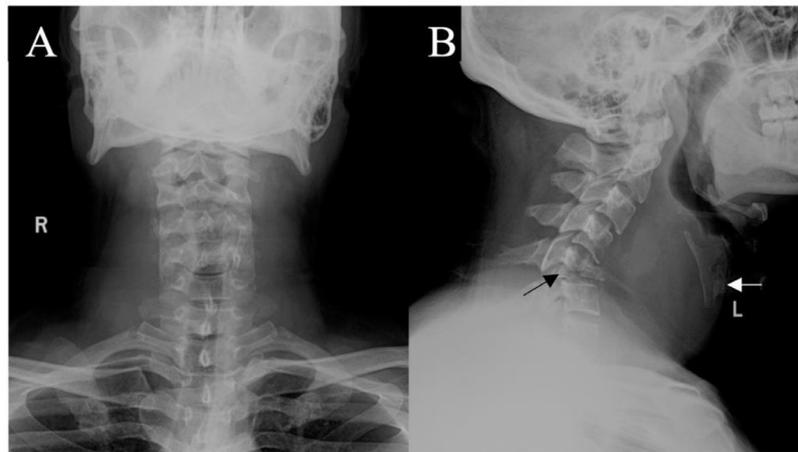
Anteroposterior (A) and lateral (B) radiographs of a 32-year-old male patient diagnosed with synovial sarcoma in the retropharyngeal space. (A) showed a large mass in the neck. (B) showed a large mass in the prevertebral space with the fifth cervical spine pathological fracture (black arrow). Thyrohyoid bone and trachea moved forward under compression (white arrow).
